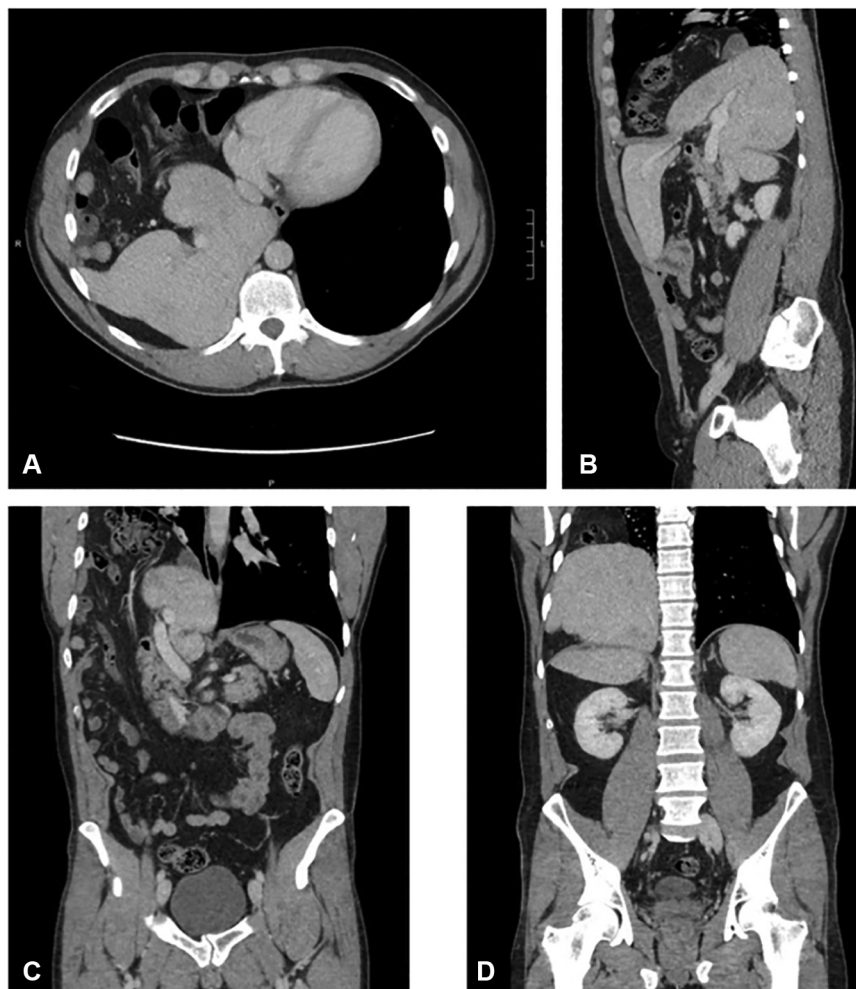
(A) Axial, (B) sagittal, and (C, D) coronal computed tomography images demonstrate the herniation of abdominal organs into the chest: a case of large traumatic diaphragmatic hernia. (C) Abdominal contents, including the portal vein, are herniated into the chest. (D) The liver can be seen above and below the diaphragm.
